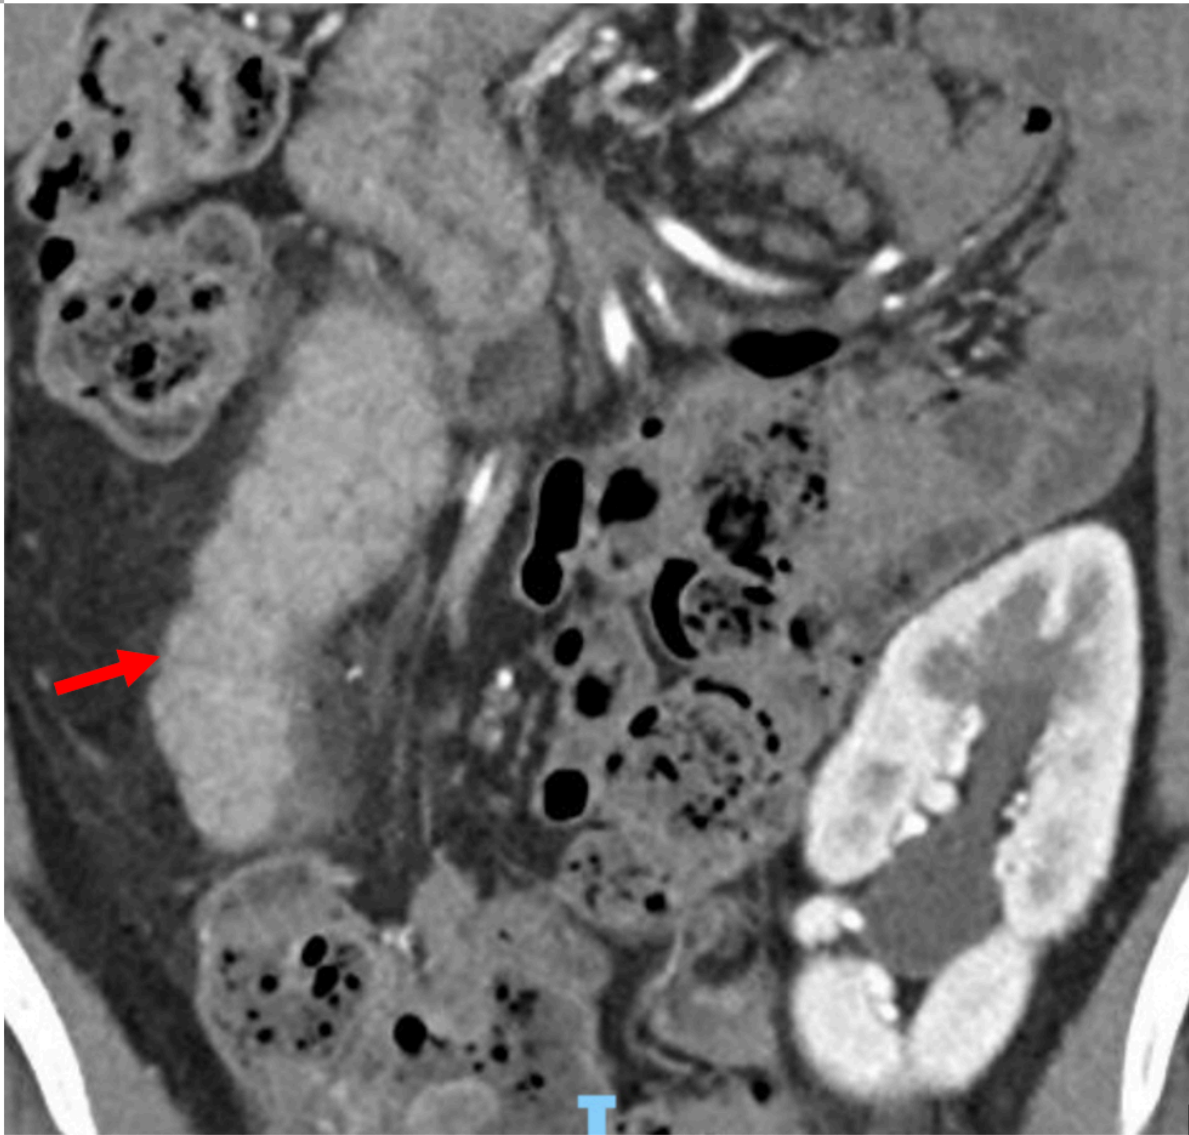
CT demonstrating parenchymal oedema and surrounding inflammatory stranding, suggestive of graft pancreatitis.
